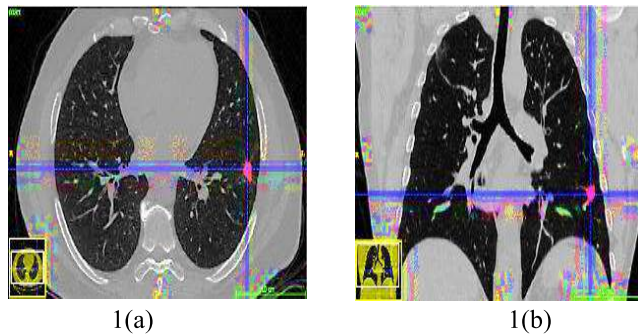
(a) Nodules segmented from the original CT scan image (b) Pulmonary nodule with chest CT image [15].
